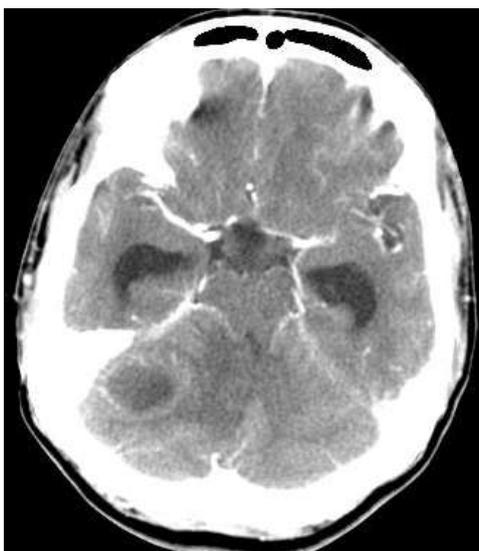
CE Axial CT scan – Rim enhancing cerebellar abscess.
